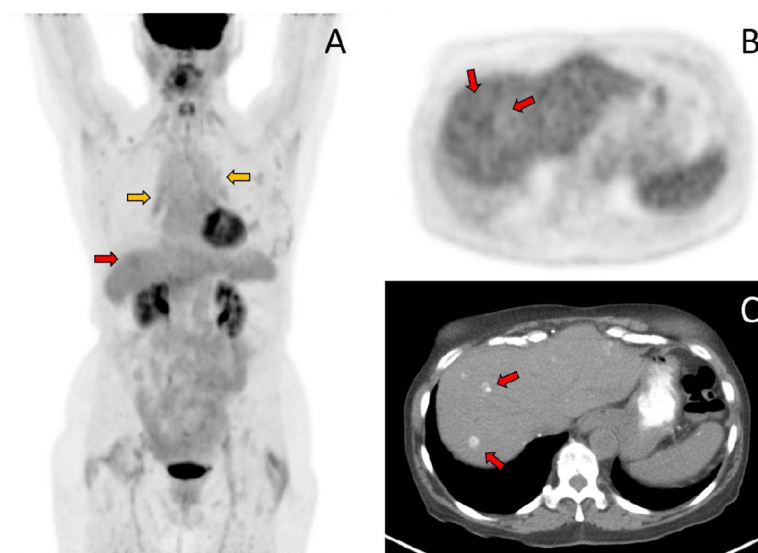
PET-CT images following 3 months of single-agent palbociclib
